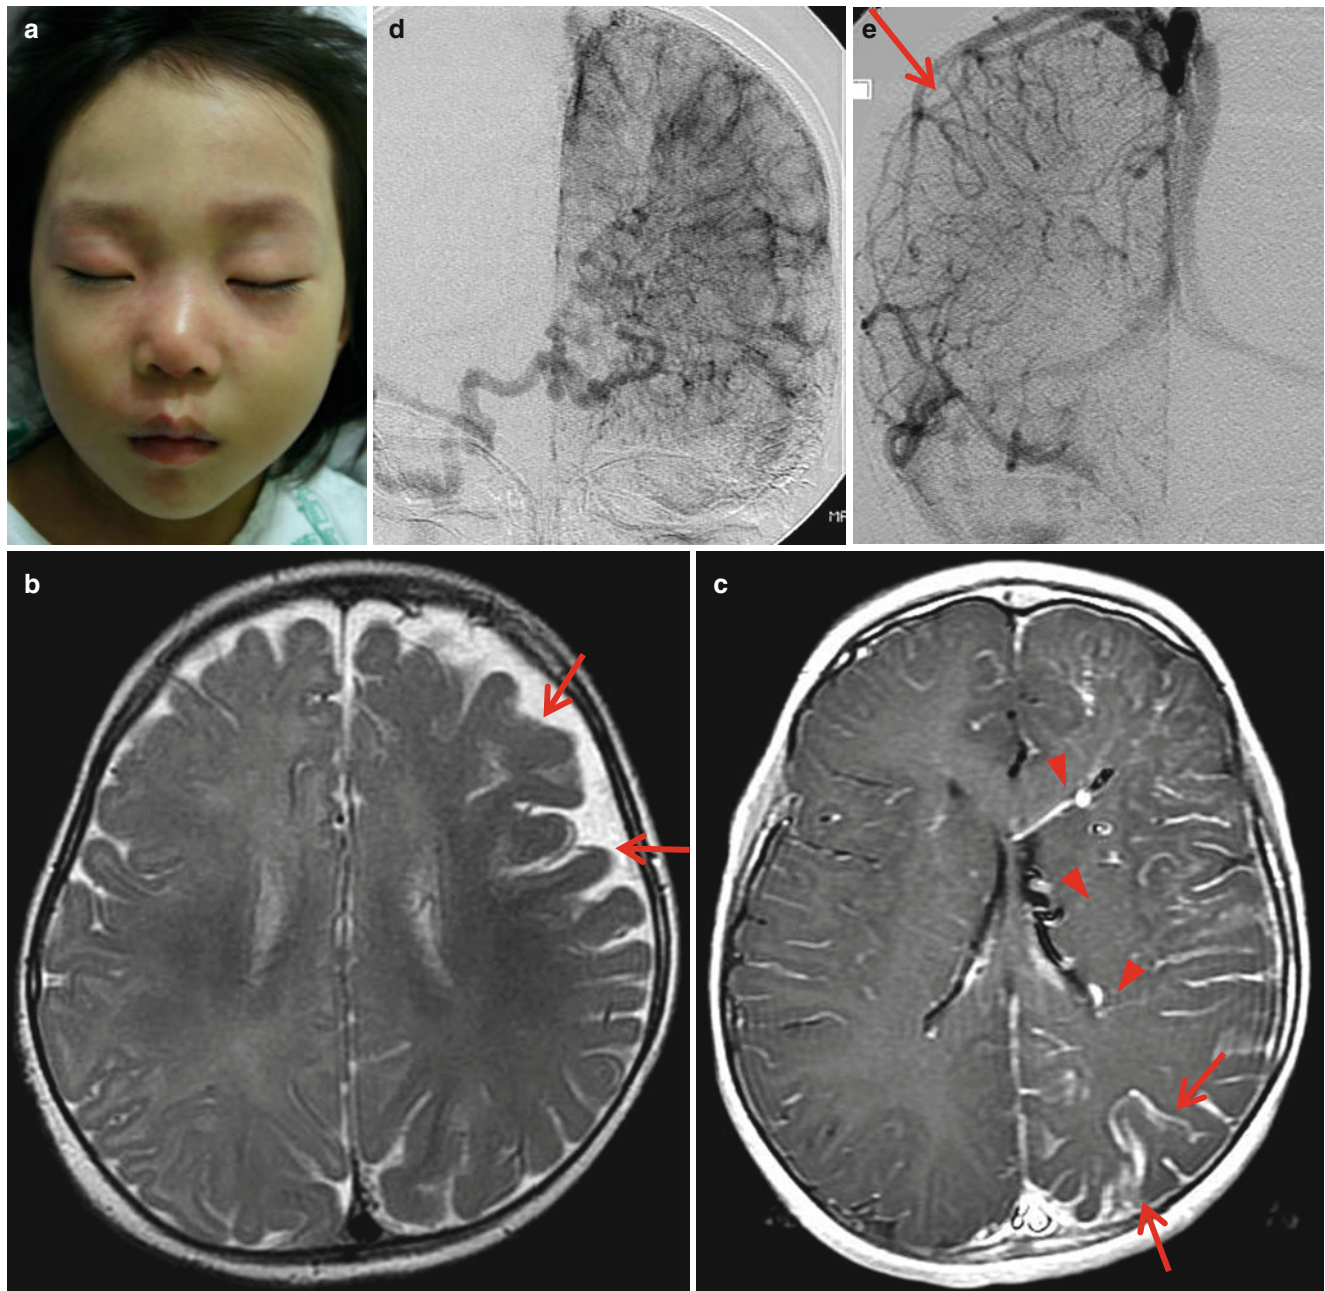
Sturge-Weber syndrome. (a) Facial port-wine nevi located over the orbital and nasal region. (b) T2-weighted image shows atrophic gyri over the left hemisphere and exaggerated low signal intensities of the left hemispheric gyri (arrows). (c) Postcontrast image shows diffuse enhancement of the leptomeningeal angiomatosis in the left
